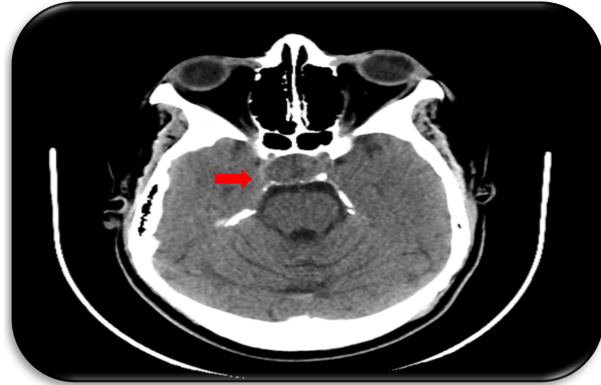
Head CT scan. Pituitary adenoma 2.5 cm × 2.8 cm, without signs of intracranial hemorrhage
